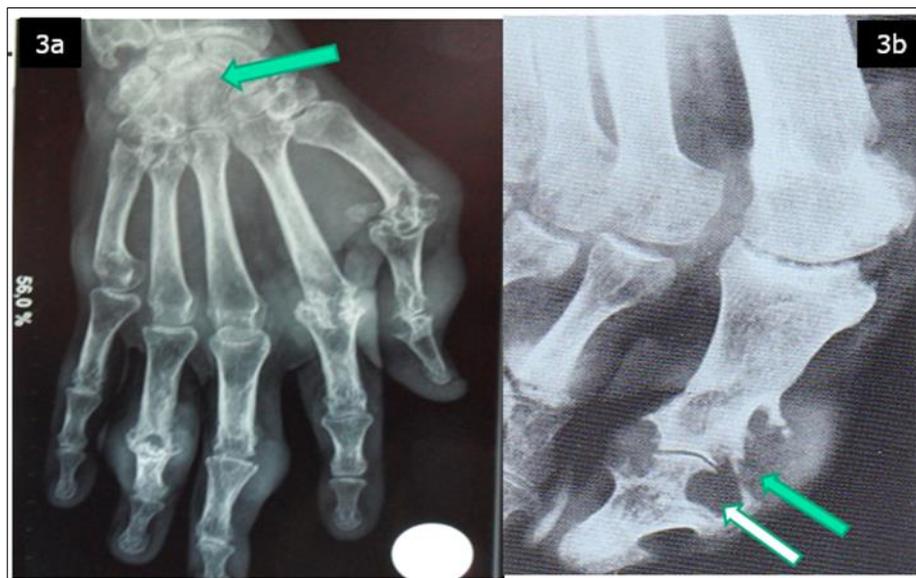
X-ray of the right hand (Fig3a) showing narrowing of the joint space of the carpal bones (Green arrow); X-ray of the right forefoot from the front (fig 3b) showing a geode or epiphyseal notch (white arrow) and a Halberd image (green arrow) image from the Rheumatology Department of Brazzaville University Hospital
